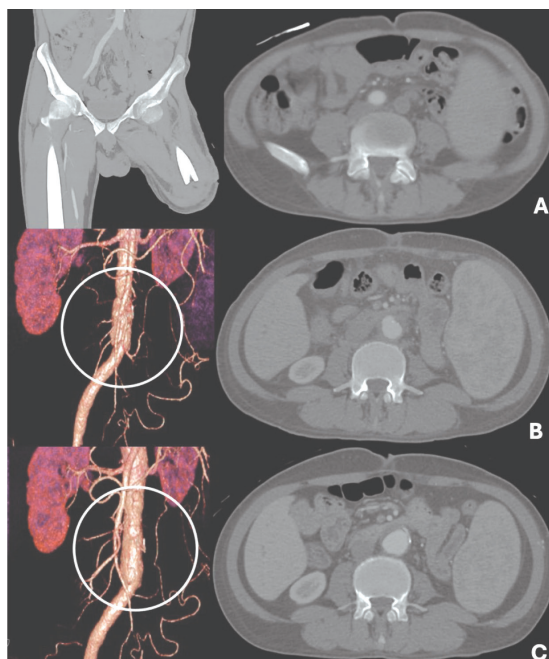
Preoperative CTA showed total occlusion of the left CIA, IIA, and EIA down to the proximal SFA (A). Postoperative CTA after 6 months showed dilatation of the abdominal aorta (B). Postoperative CTA after 36 months showed no progression of the abdominal aorta (C). Lifelong follow-up appointments, including clinical examinations and inflammatory marker tests such as ESR and CRP, were scheduled every 3 months, with a CTA scan at 3 months postoperatively and then every 6 months thereafter.
